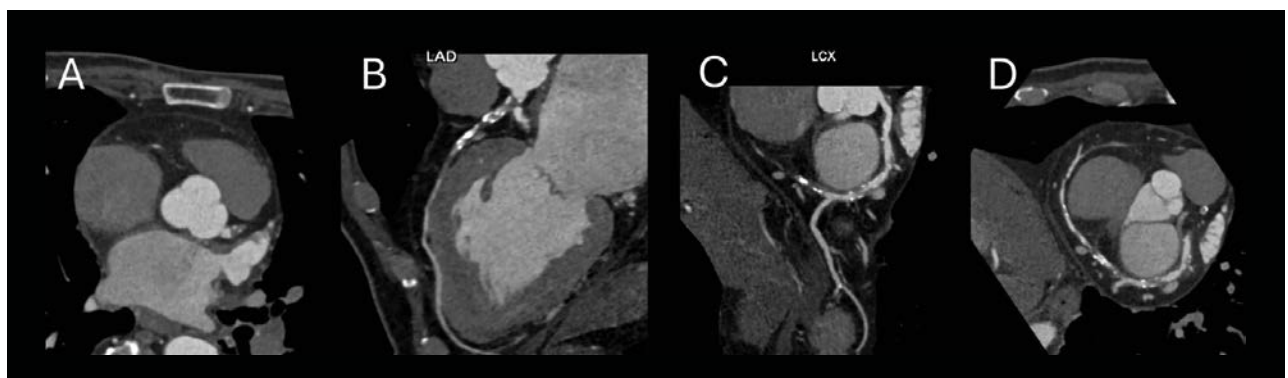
Curved range radial multiplanar reformation (MPR) images obtained through Coronary CT angiogram at coronary sinus level (Fig 2A), LAD (Fig 2B), LCx (Fig 2C) and an artery courses through the crux of the heart.
